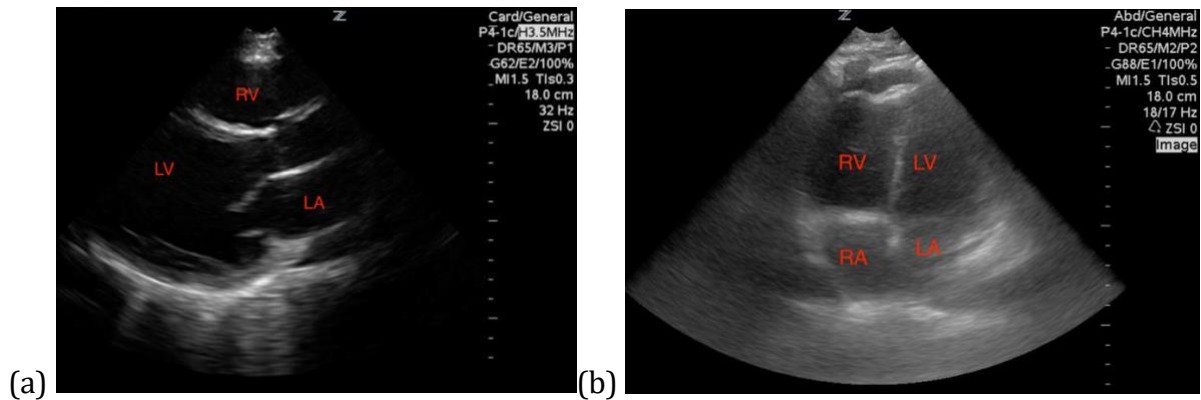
Standard cardiac windows include (a) PLAX and (b) apical 4 chamber (Images courtesy of Dr. Zachary Soucy, Dartmouth Hitchcock Medical Center)
